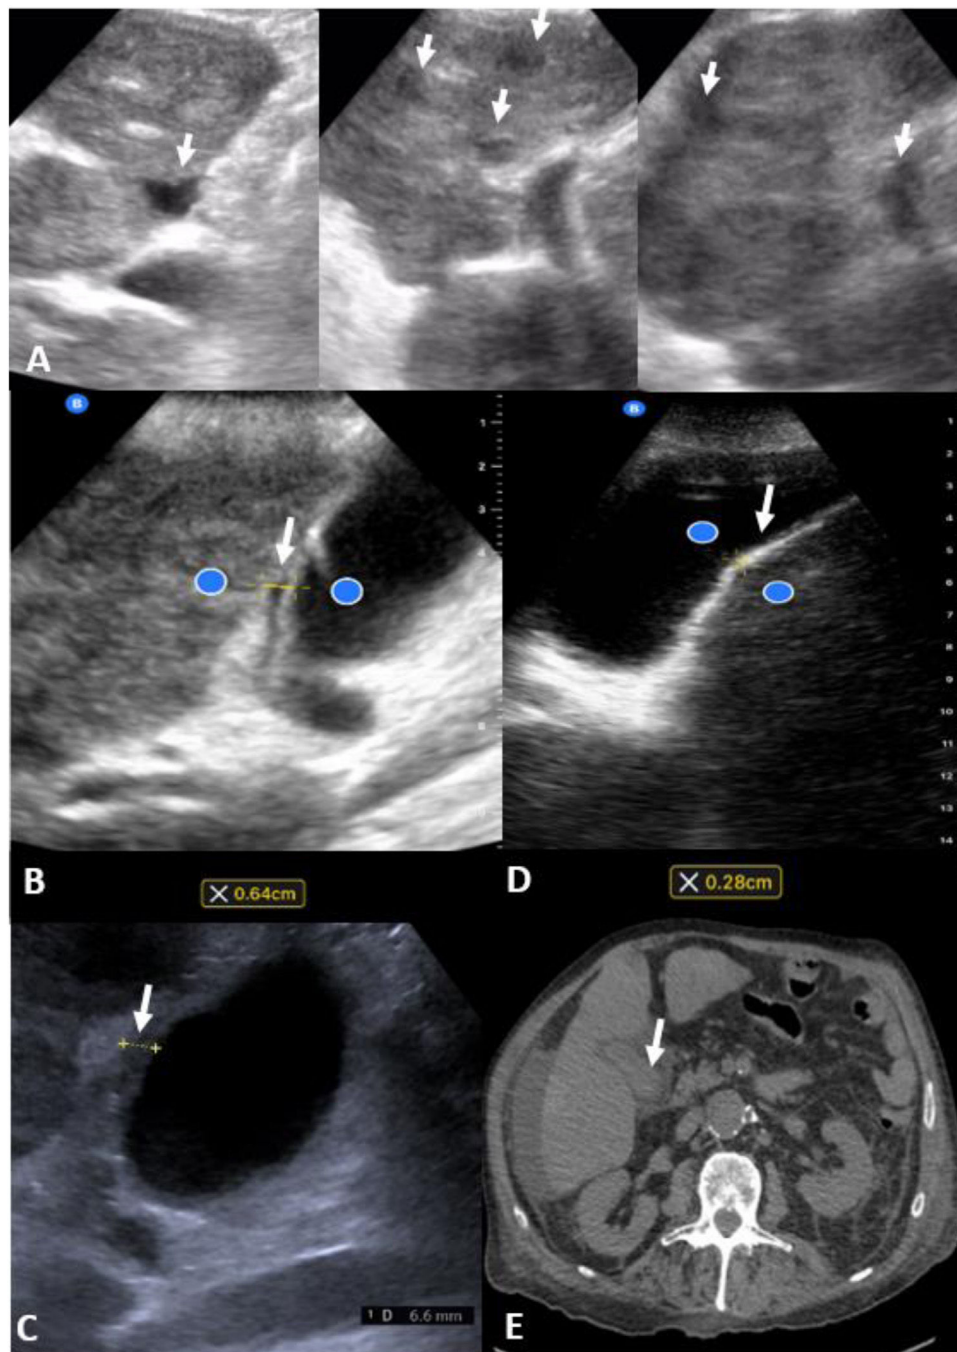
(A) Point of care ultrasound of liver with multiple rounded anechoic and hypoechoic zones. (B) Point of care ultrasound of gallbladder (trilaminar wall pointed with the arrow). (C) Regulated Ultrasound of gallbladder (trilaminar wall pointed with the arrow). (D) Point of care ultrasound of gallbladder after antibiotic treatment (wall pointed with the arrow, observe it is normal wall pointed with the arrow). (E) Computerized tomography thorax-abdomen-pelvis, which does not assess gallbladder walls (gallbladder pointed with the arrow).
